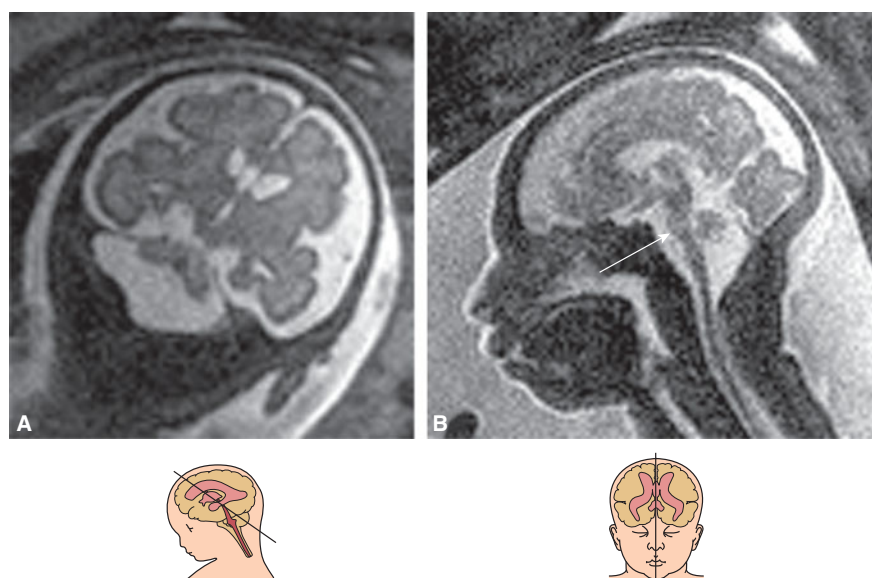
In this fetus with cerebellar hypoplasia, MRI demonstrated a very thin brainstem with no bulging of the pons (arrow). The forehead is sloping, suggesting microcephaly. This is an example of pontocerebellar hypoplasia. (Courtesy Rabih Chaoui, Berlin, Germany.)
